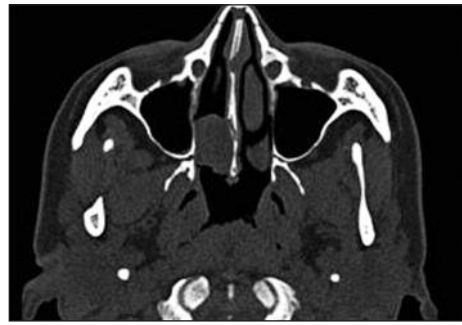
Axial CT of paranasal sinus shows the soft tissue mass originating from the right middle turbinate.
